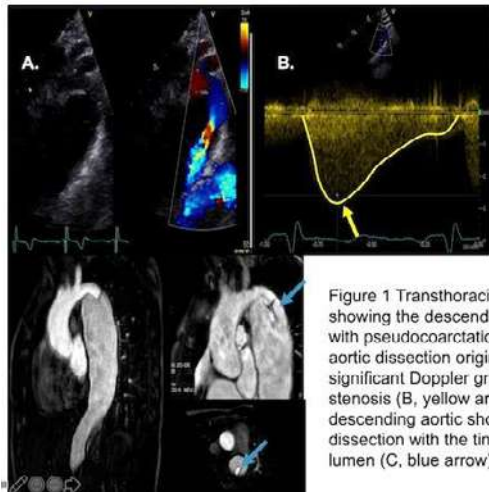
Transthoracic echocardiography: showing the descending aorta with pseudocoarctation at level of the aortic dissection origin (A) and the significant Doppler gradient across the stenosis (B, yellow arrow). The MRI of the descending aortic shows the type B dissection with the tiny contrast filled true lumen (C, blue arrow).
